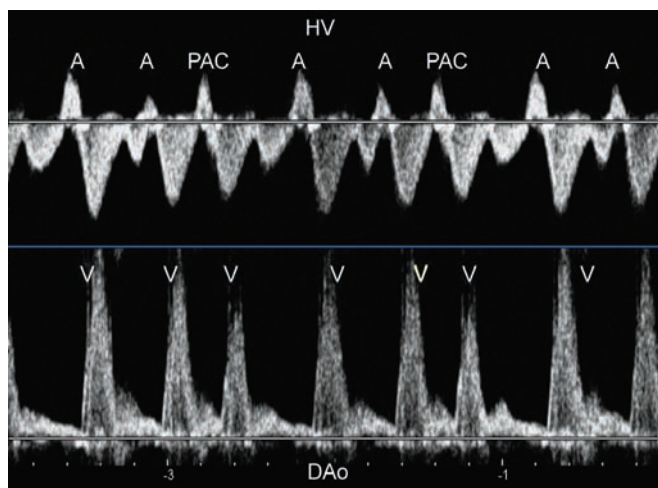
Dual Doppler recordings of the HV and DAo from a fetus with trigeminy with PAC. Doppler waveforms in HV (above) and DAo (below) are shown. Both ventricular systolic flow in DAo and atrial systolic flow in HV are trigeminal
